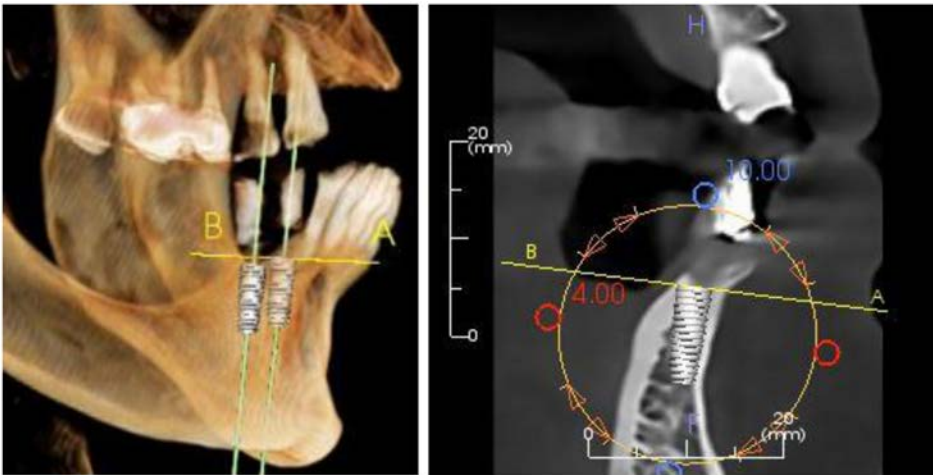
CT scan images for implant placement planning.
